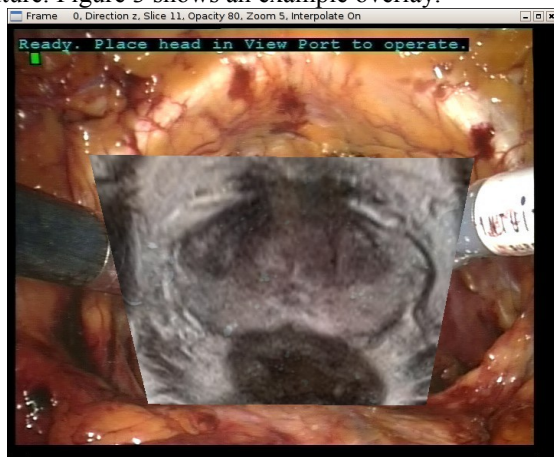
A transverse MRI slice projected onto endoscopic video. The surgeon can move through the MRI volume, change the slice direction and opacity.
